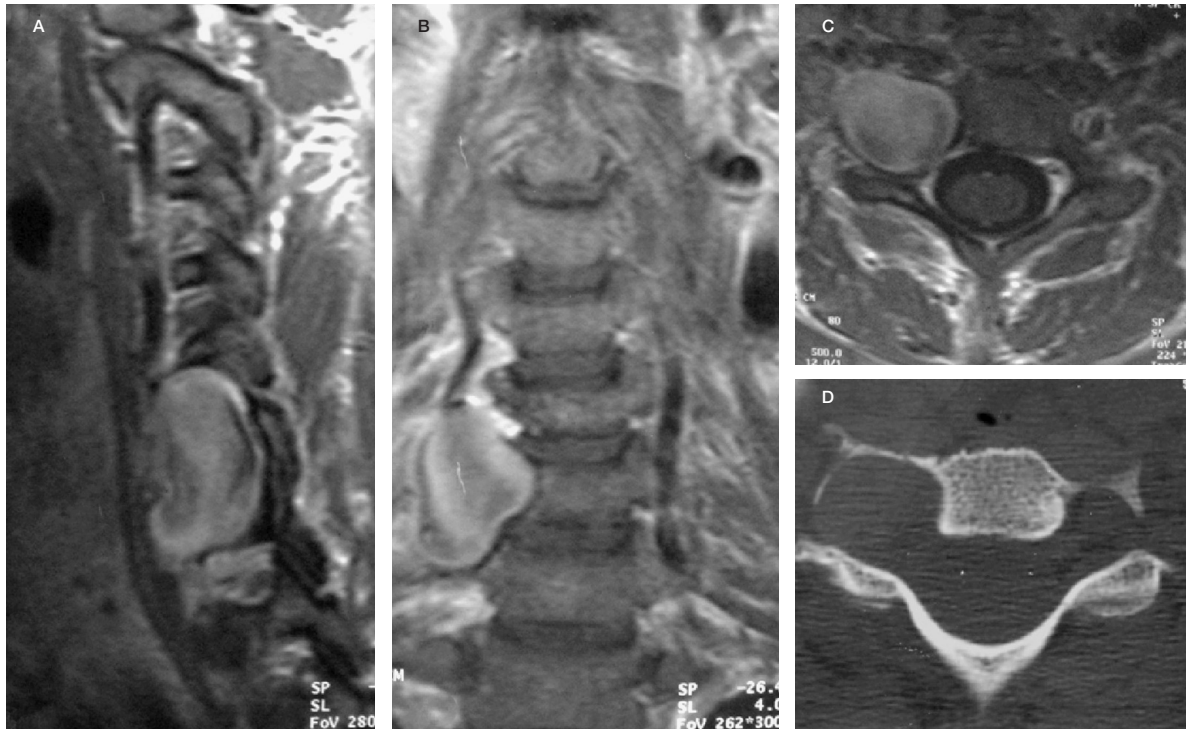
Case 4. On T2W MRI sequences enlargement of transverse foramen due to a mass presumably representing a large aneurysm (high signal due to low flow and turbulence) can be seen that demonstrates contrast enhancement (A-C: T1 weighted images after contrast) and bone erosion on CT (D). Adjacent structures are compressed.
